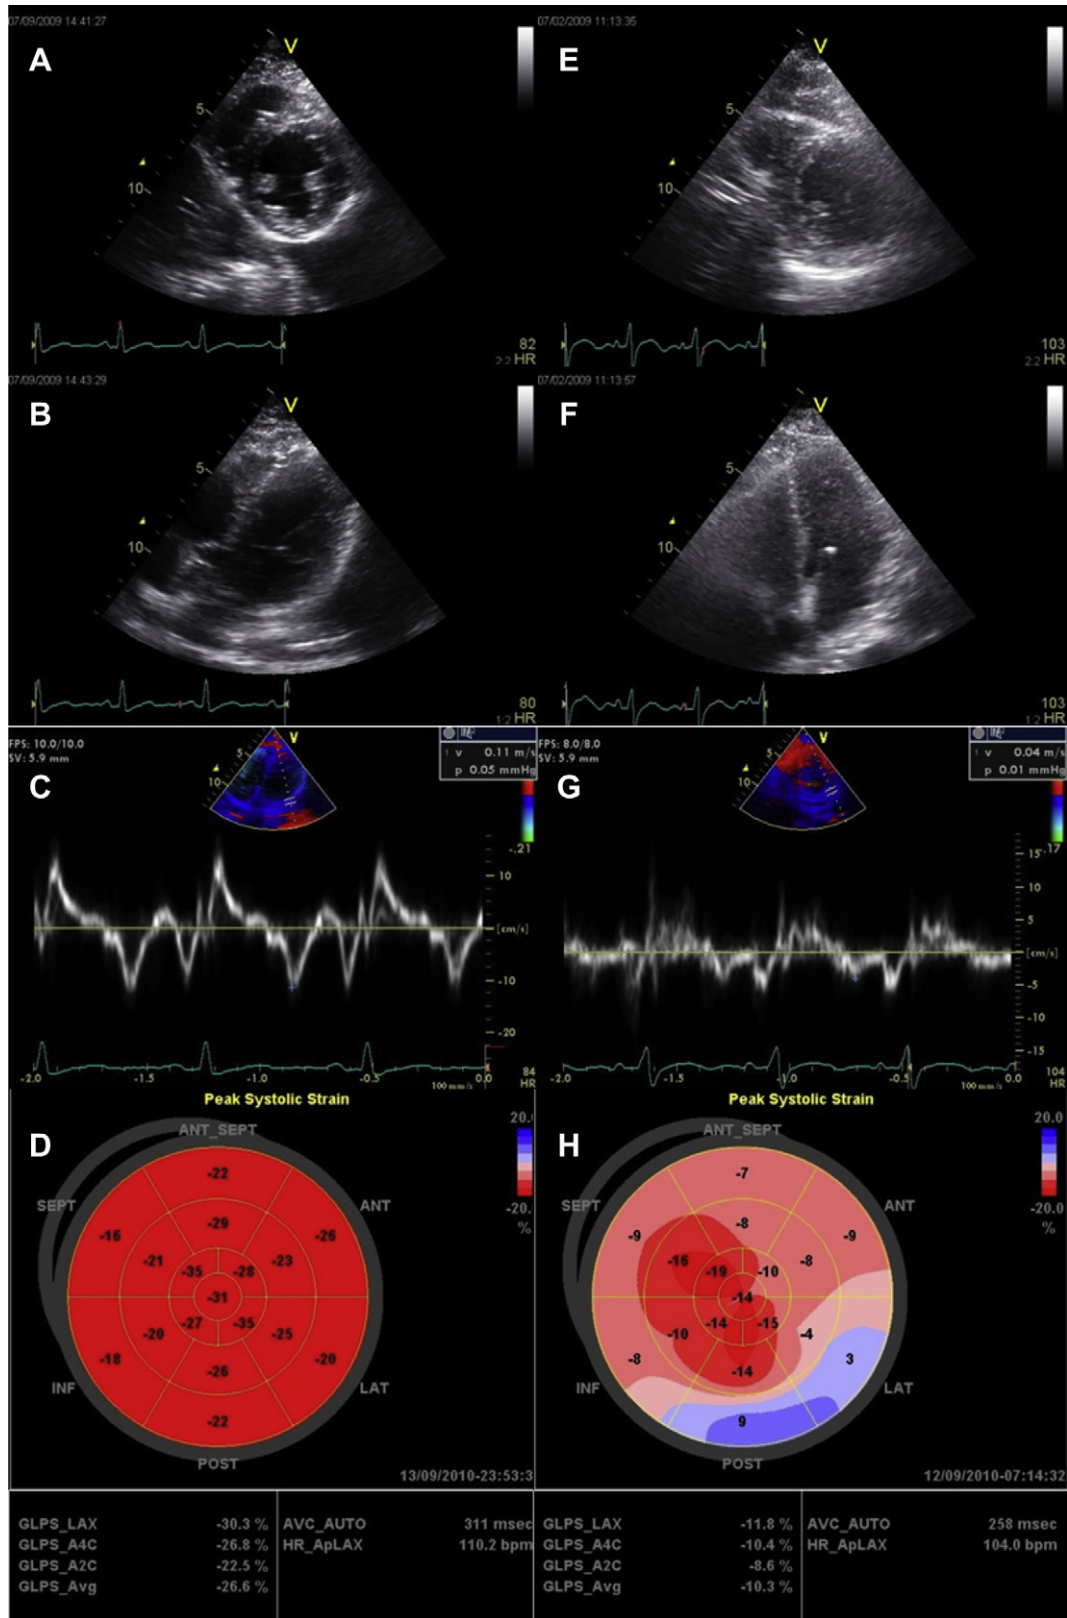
(A–D) A normal adult without heart failure (HF) and free from systemic diseases; (E–H) a case with hypertension, old stroke, renal insufficiency and HF symptoms. (A,E) Both patients had normal left ventricular (LV) ejection fraction and preserved short-axis function without visible regional wall motion abnormality. Apical four-chamber view (B,F) showing preserved LV function and tissue Doppler imaging (TDI) revealed preserved (C:11 cm/s) and severely impaired diastolic function (G: 4 cm/s), respectively. Bull's-eye display imaging by automatic functional imaging from all three apical axis (D) showed preserved global longitudinal strain (mean: -26.6%) and (H) decreased longitudinal global strain (-10.3%) indicating impaired global longitudinal systolic function in HF patient. (Figure produced and processed by Lo, Chi-In MD, Mackay Memorial Hospital Taipei, Taiwan.) BMI = body mass index.
